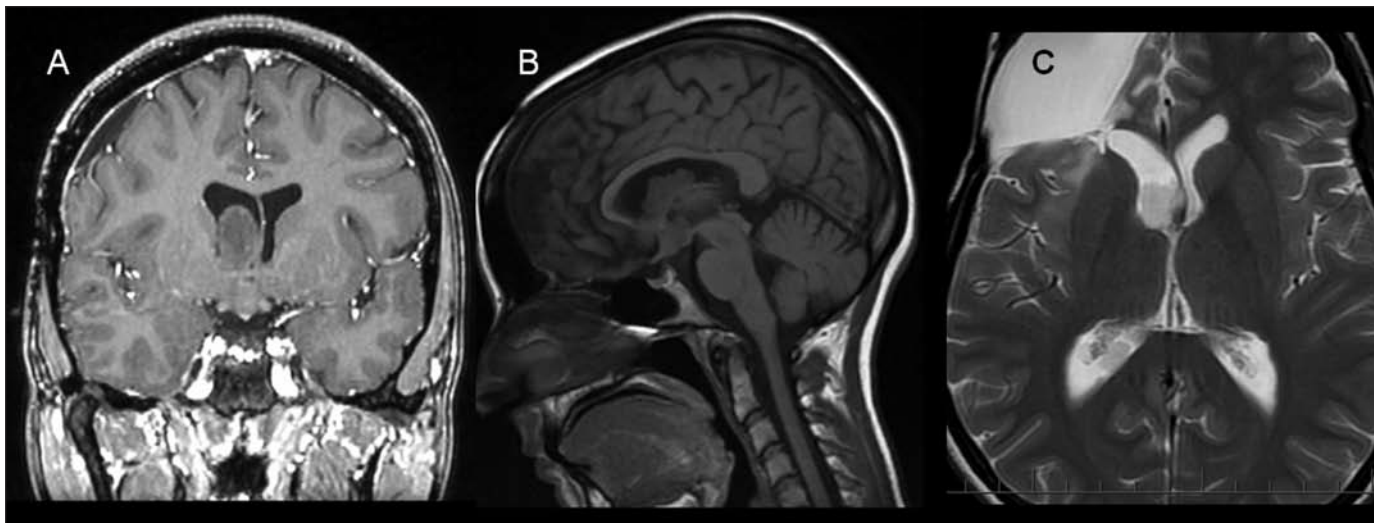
A: Coronal T1-weighted Post Gadolinium (by 1.5 Tesla GE Sign Excite); B: Sagittal T1 FLAIR; C: Axial T2-weighted: images showing three intraventricular lobulated masses: the first arising from the floor (A) of the right lateral ventricle and the second one involving the atrium (C) of the same ventricle. The third one is seen in the anterior recess region of the third ventricle (B).
